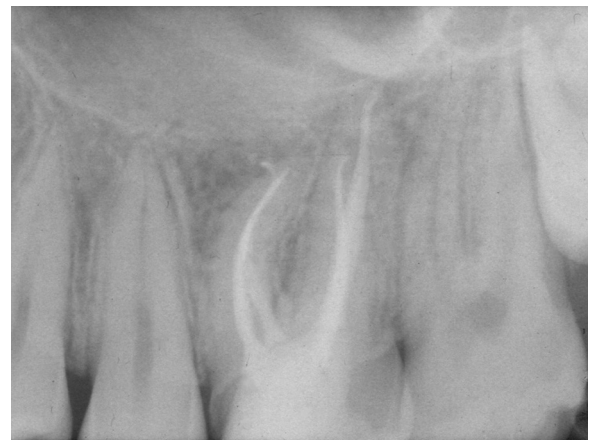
Post-operative radiograph of 2.6. Shaping was obtained with ProTaper Next.
